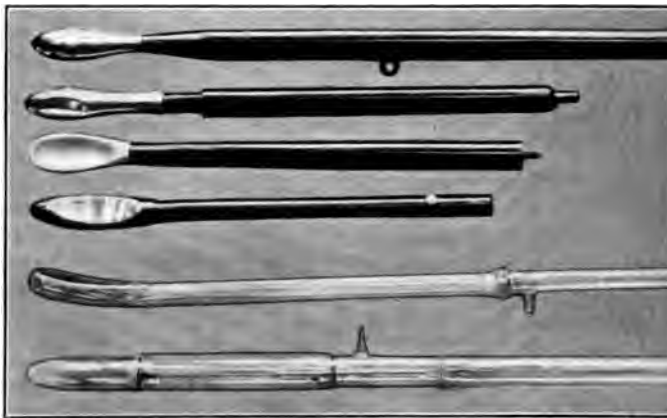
Metal and glass rectal electrodes. From above downward: tipped hard rubber handle electrodes, respectively called elongated olive rectal electrode, elongated olive with flat face, seminal vesicular electrode, spoon-shaped rectal electrode, hard rubber with metal face prostatic electrode. Then come the x-ray vacuum high-tension glass prostatic electrode and the cone point of the same type.
